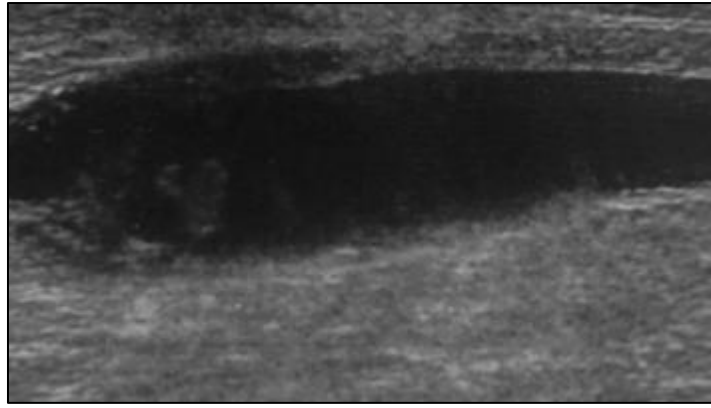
Longitudinal B-mode ultrasonography of the left calf showing a complex, predominantly anechoic fluid collection containing low-level internal echoes and extending beyond both lateral margins of the acquired image, consistent with fluid dissection following rupture of a Baker's cyst.
